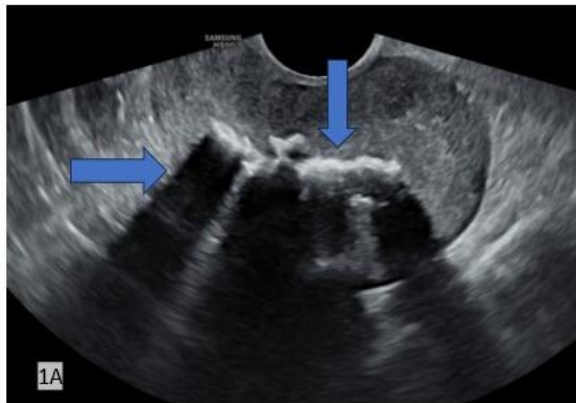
(A). Transvaginal longitudinal USG images show a retroverted uterus with dense echoes in the endometrial cavity(vertical blue arrow) with excessive posterior acoustic shadowing(horizontal blue arrow) causing a nearly completely obscured posterior wall of the uterus. 1(B). Absence of obvious vascularity on Colour Doppler.
